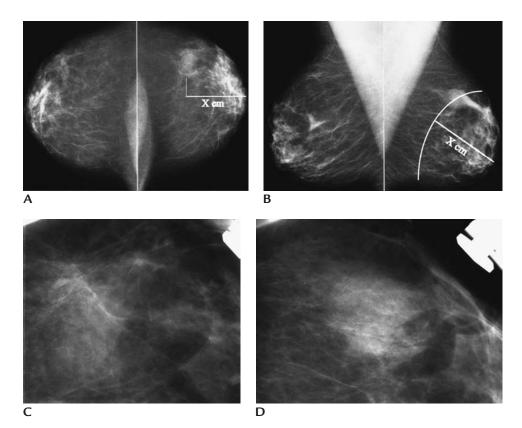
Focal parenchymal asymmetry. (A) Craniocaudal views. Parenchymal asymmetry is noted laterally in the left breast. (B) MLO views. Comparable rounded area of asymmetry is noted corresponding in size and location to area seen on the craniocaudal view. Review of prior films is helpful. If there are no prior films available, or this represents a new finding, the patient is called back for additional views. (C) Spot compression view, CC projection and (D) spot compression view, MLO projection. Although a rounded area of tissue is seen on the MLO spot, no abnormality is apparent on the CC spot compression view. On physical examination, normal tissue is palpated throughout the upper outer quadrant of the left breast and normal tissue is imaged in this quadrant sonographically.
